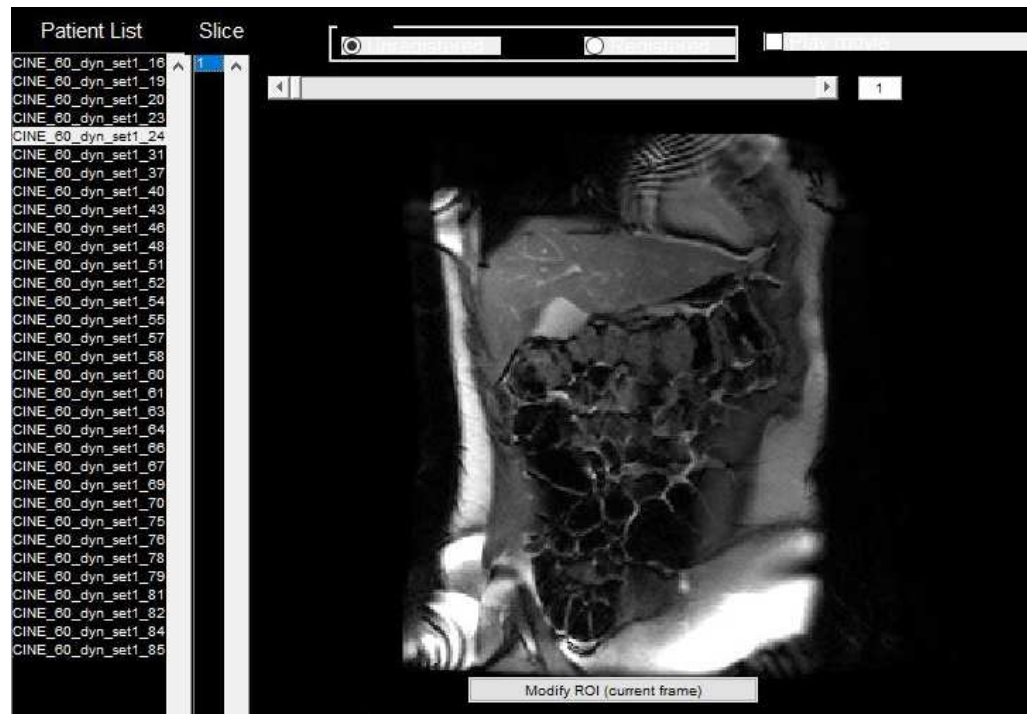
An example of a specific MRI set selected when its folder is loaded on Matlab.
